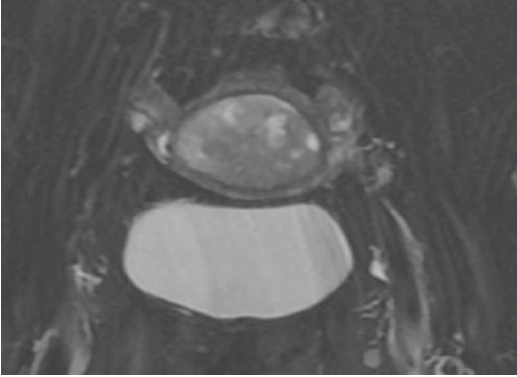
Axial T2-weighted MRI showing the large mass filling the endometrial cavity. Intact junctional zone clearly demonstrated with no extension of mass into the myometrium
